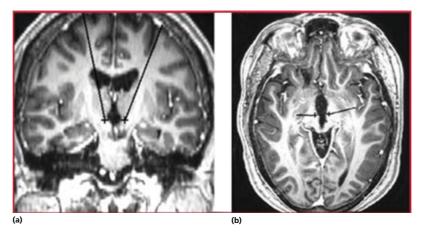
Reconstructed electrode trajectories towards the posterior hypothalamus superimposed on pre-operative coronal (a) and horizontal (b) MRI scans. Source: Kuhn *et al.* [71]. Reproduced with permission of Karger.
